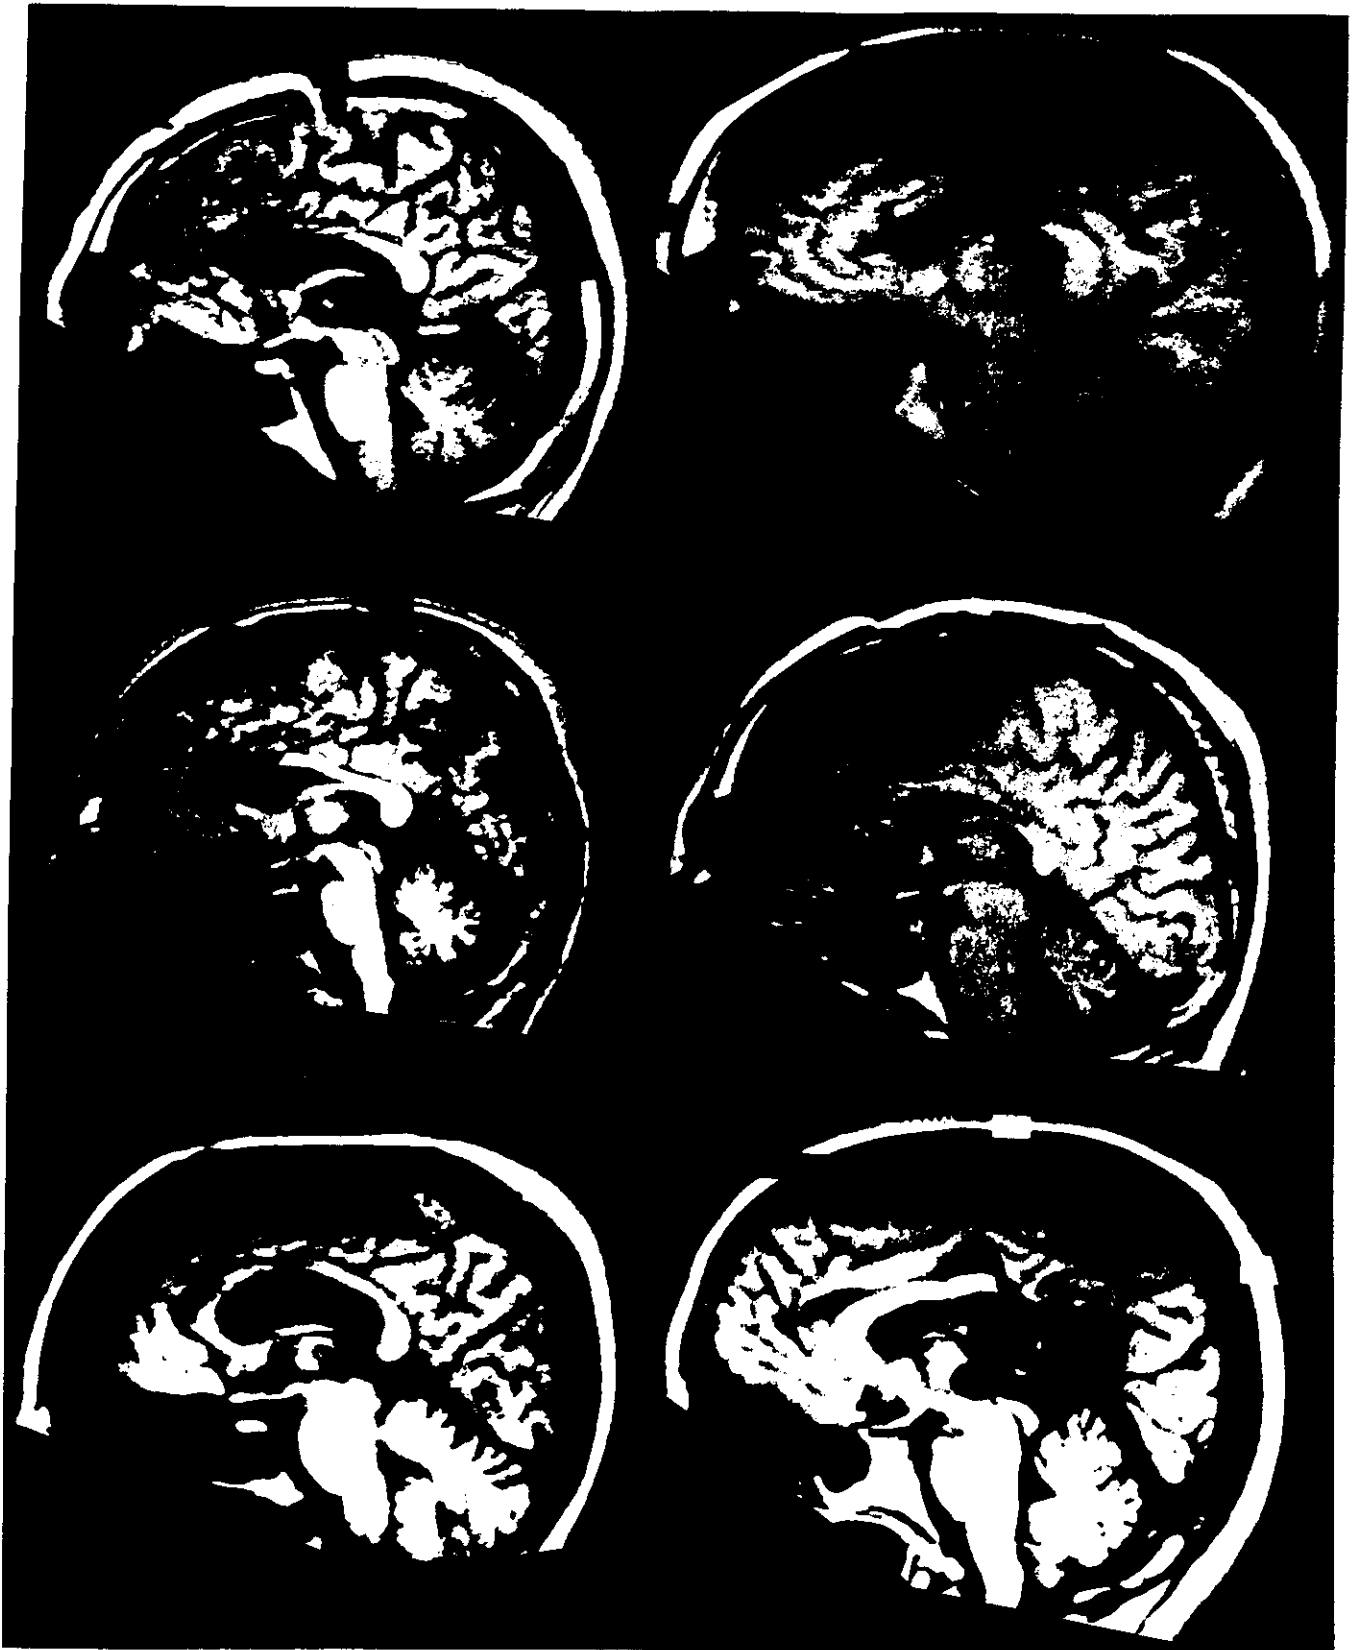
MRI sagittal view of the brain of callosotomy patients C.G. (top left), F.P. (top right), G.E. (middle left), I.D. (middle right), V.G. (bottom left) and of patient Z.A. with an intracerebral AV malformation (bottom right). The anterior callosal section is most extensive in I.D. and least extensive in G.E.
